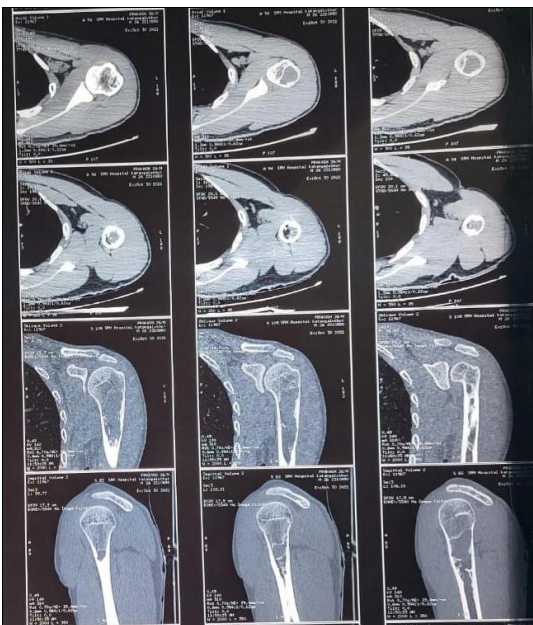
MRI sections showing Lesion
